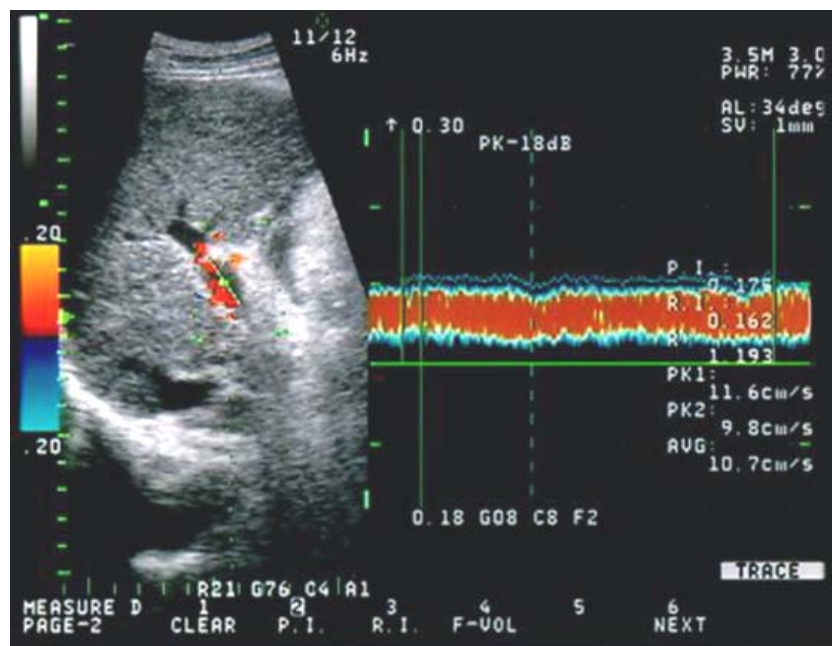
Portal venous velocity measured with Doppler US (10.7 cm/s) in a patient with cirrhosis.
